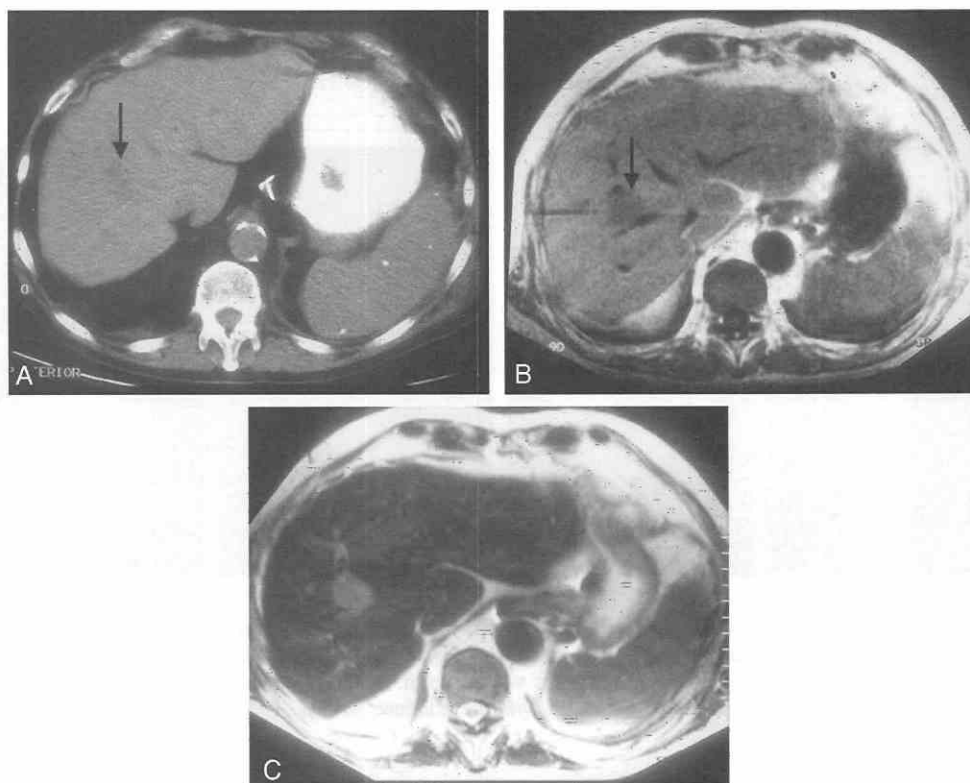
A, CT scan shows a very subtle lesion on an unenhanced scan. Because of the proximity of vessels and poor visibility, it was decided to biopsy the mass under MRI. B, T1-weighted scan shows a subtle mass in the mid-right lobe of the liver. C, T2-weighted scan shows increased signal in the lesion, which was biopsied under MR guidance and proved to be metastatic cholangiocarcinoma.
